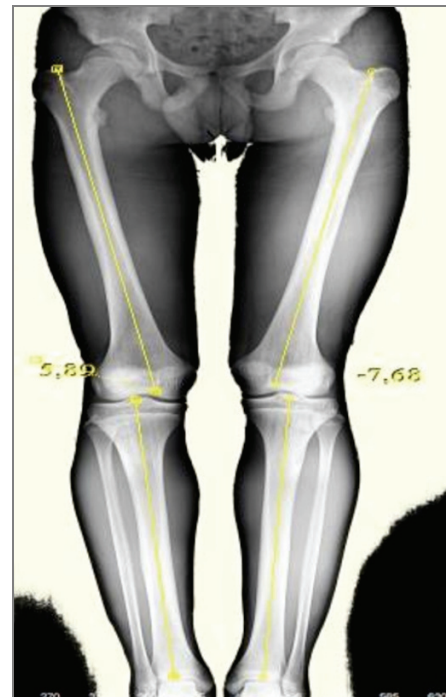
Evaluation of lower extremity alignment in the frontal plane using leg length radiograph
